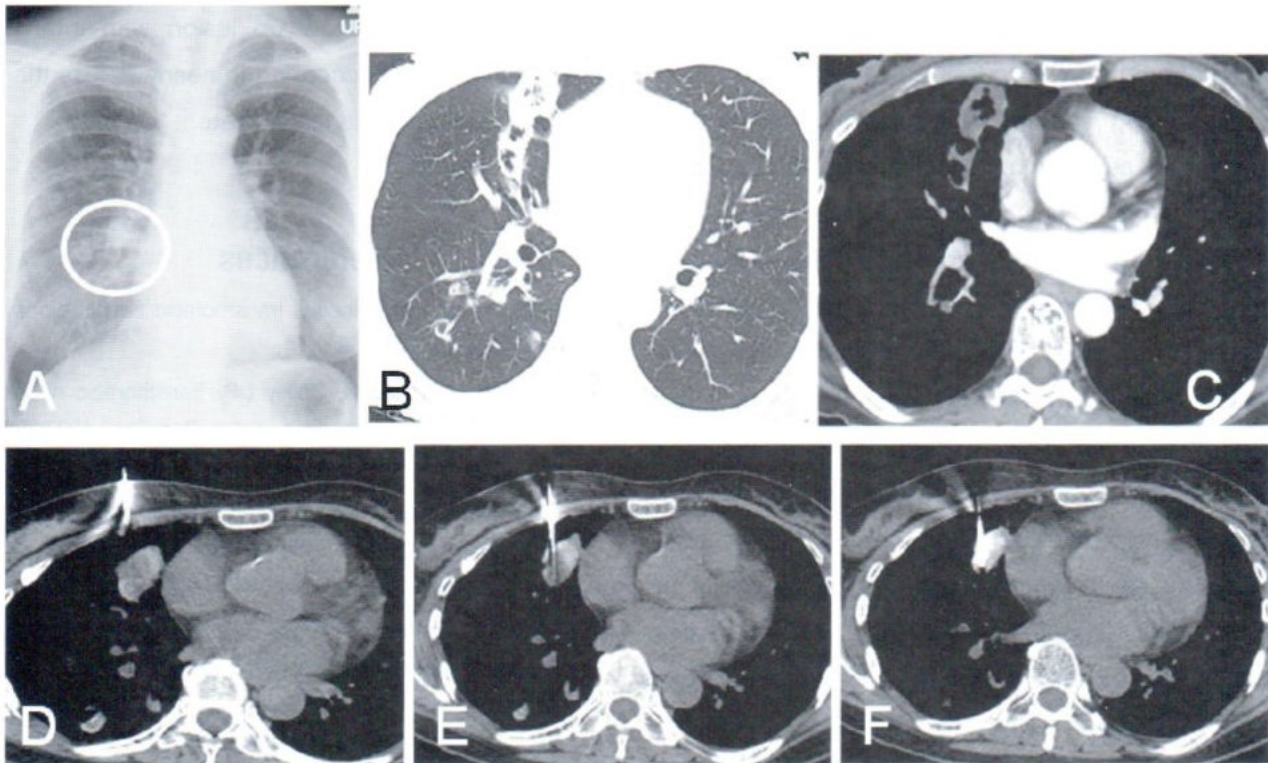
A 48 years old woman known case of Rheumatoid arthritis presented with multiple pulmonary masses (A). CT scans of chest was done and showed multiple pulmonary nodules and some of them have cavitory formation (B, C). Percutaneous transthoracic Core needle biopsy was performed by using Semi automatic cutting devices No.18 G X I attempt (D, E, F) at the RML mass and pathological report showed Cryptococcosis.
